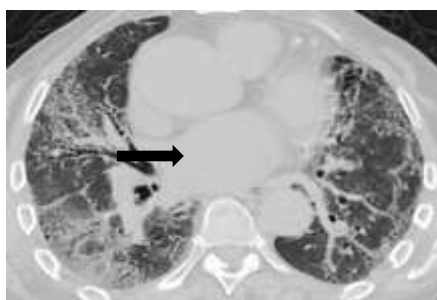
Traction bronchiectasis. Axial HRCT image of the both lower lung lobes showing basal predominant reticulation adjacent to traction bronchiectasis (arrow).
